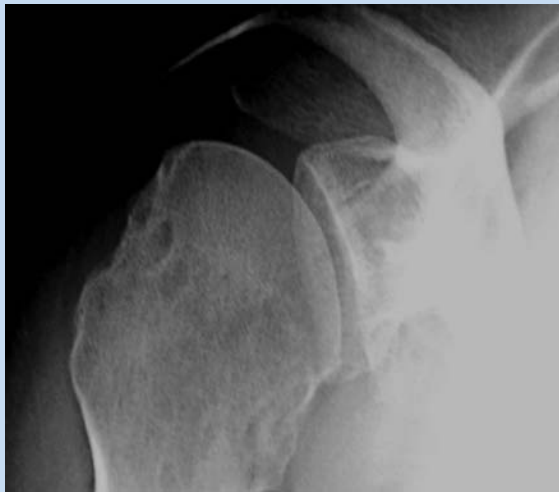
Apical oblique view. A radiographic cassette is placed flat against the scapula on the affected side while the patient sits with his or her arm in the lap. The radiographic beam is focused on the coracoid process, perpendicular to the cassette, except that it is angled 45° caudally off the anteroposterior glenohumeral view. This allows the beam to be tangential to the anteroinferior aspect of the glenoid rim.
